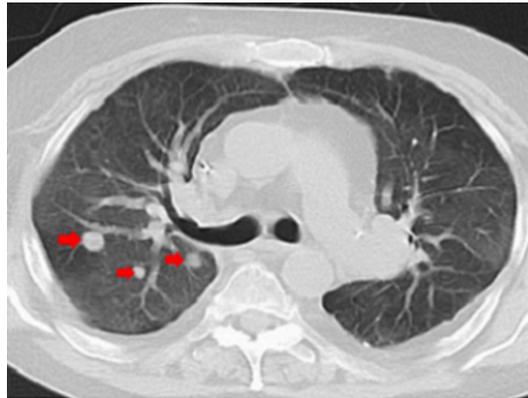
Chest CT showing multiple pulmonary nodules in the right lower lung field (red arrows).
